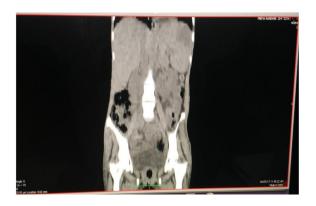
CT abdomen splenic infarct
